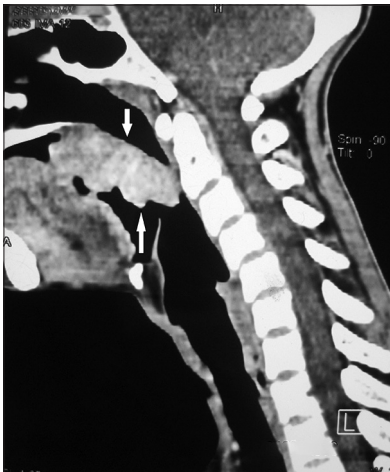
Computed tomography sagittal view showing soft tissue mass (marked by arrow) arising from soft palate reaching up to the posterior pharyngeal wall causing obliteration of nasopharyngeal and oropharyngeal airway
